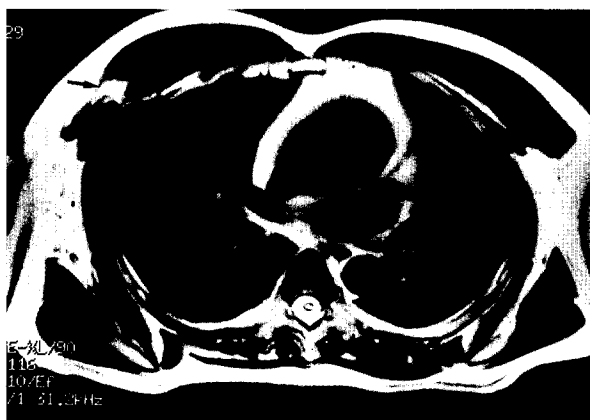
T2-weighted image shows a 3 x 1.5 cm hyperintense shadow (arrow) over the musculotendinous junction compatible with massive partial tear of the pectoralis major.
